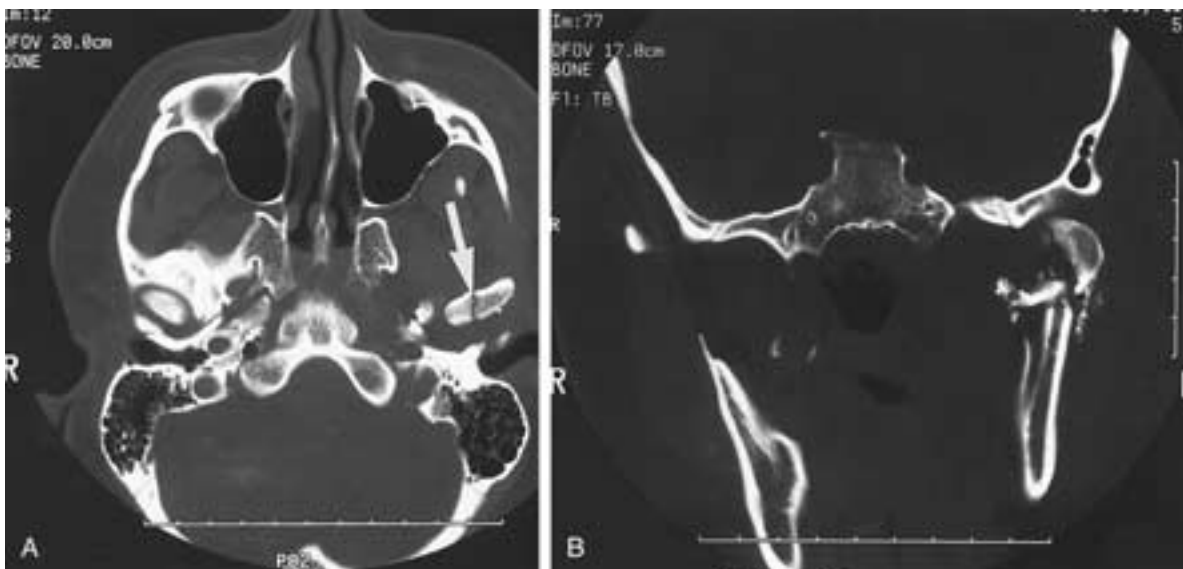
Penetrating trauma to the TMJ. A, Axial CT scan through the condyle shows a sagittal fracture in the center of the condyle head. B, Coronal image through the joint shows comminuted fractures with displacement of the medial fragment. Axial and coronal views are supplementary because the displacement was not well appreciated on the axial image.
